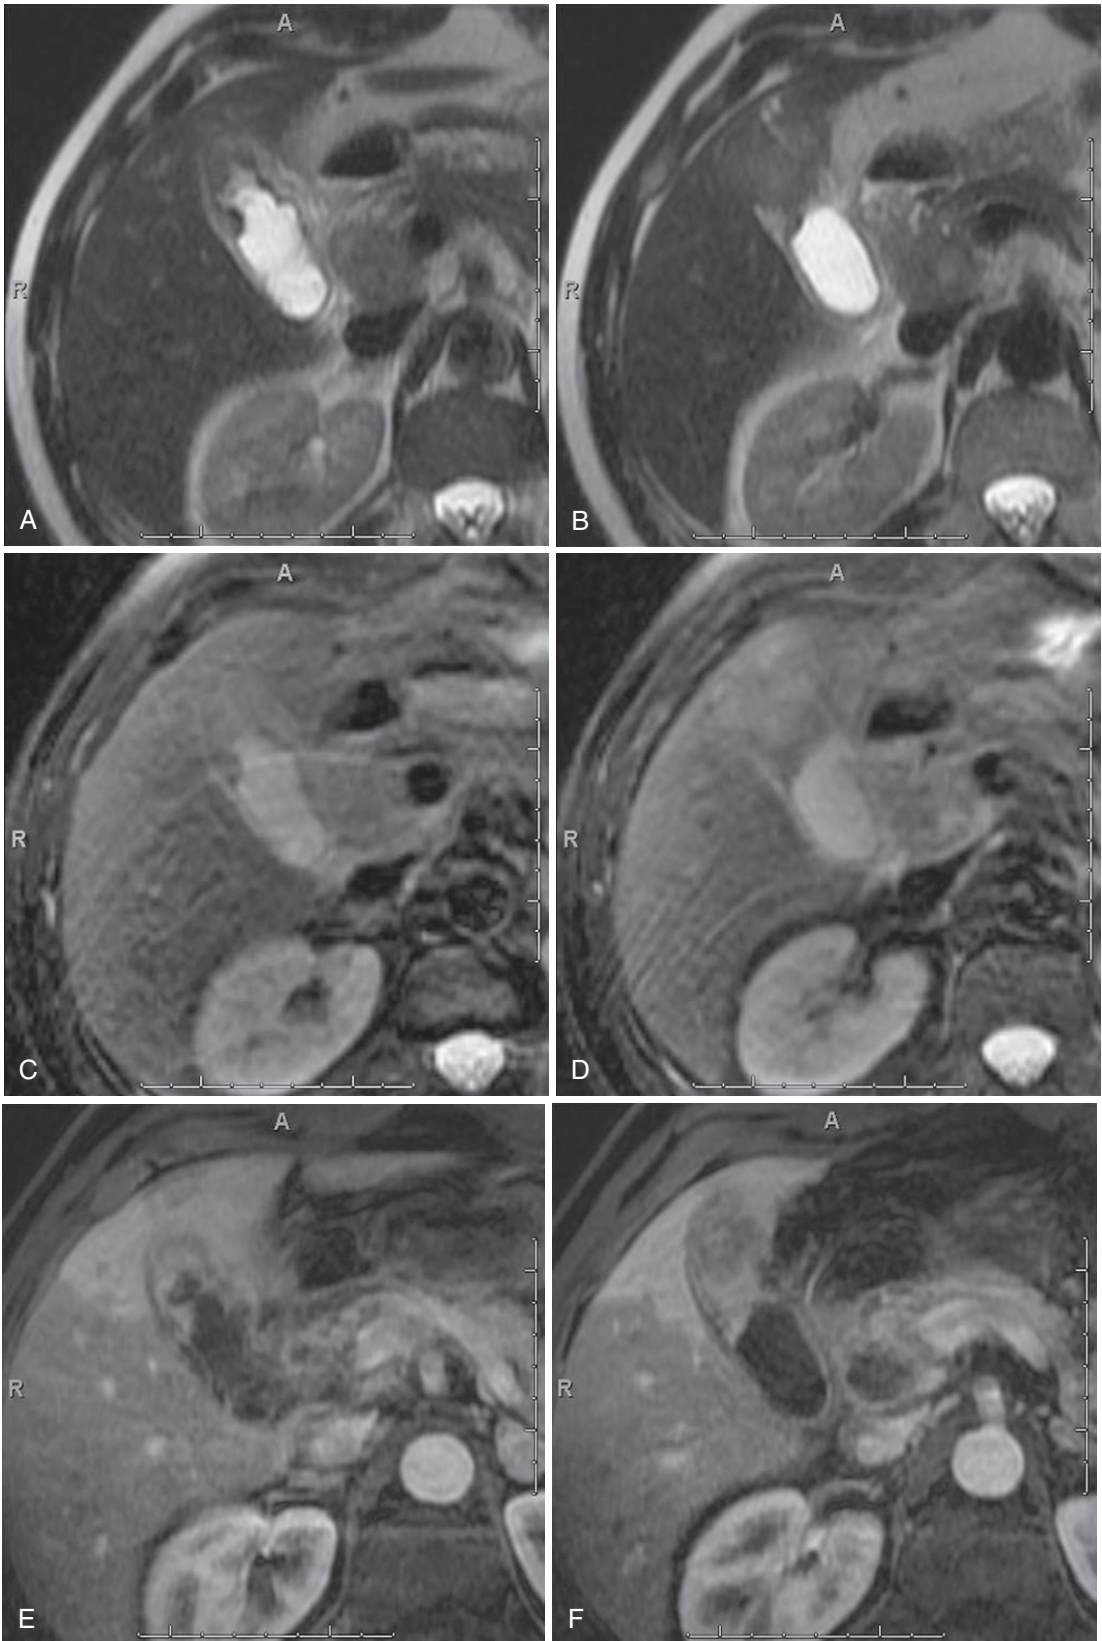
Gallbladder carcinoma with local invasion. Superior and inferior T2-weighted (A and B), fat-suppressed T2-weighted (C and D), and postcontrast fat-suppressed T1-weighted gradient recalled-echo (E and F) images demonstrate an enhancing soft tissue mass at the fundus of the gallbladder with direct invasion into the adjacent hepatic parenchyma, in keeping with gallbladder adenocarcinoma.
